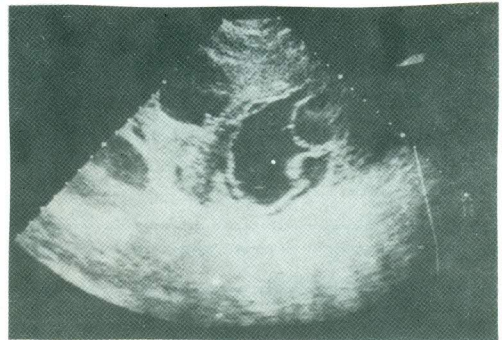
Abdominal ultrasound of the same patient with multiple hepatic hydatid cysts with cyst within cyst appearance in the largest one of them.
